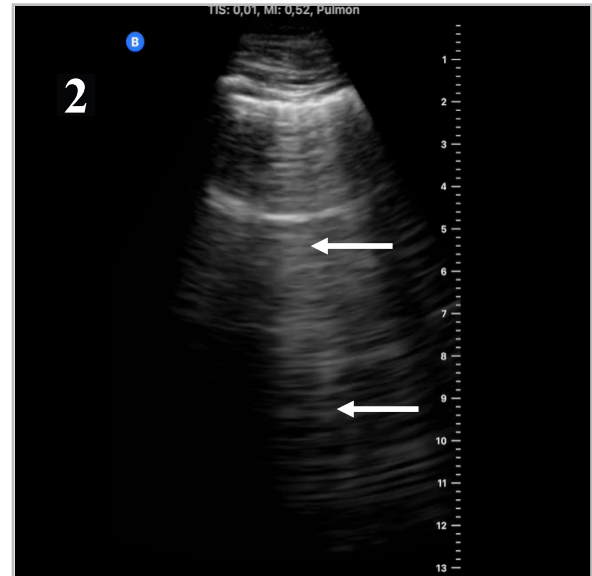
Lung ultrasound (LUS) image with a symmetrical B pattern and a gravitational gradient.
